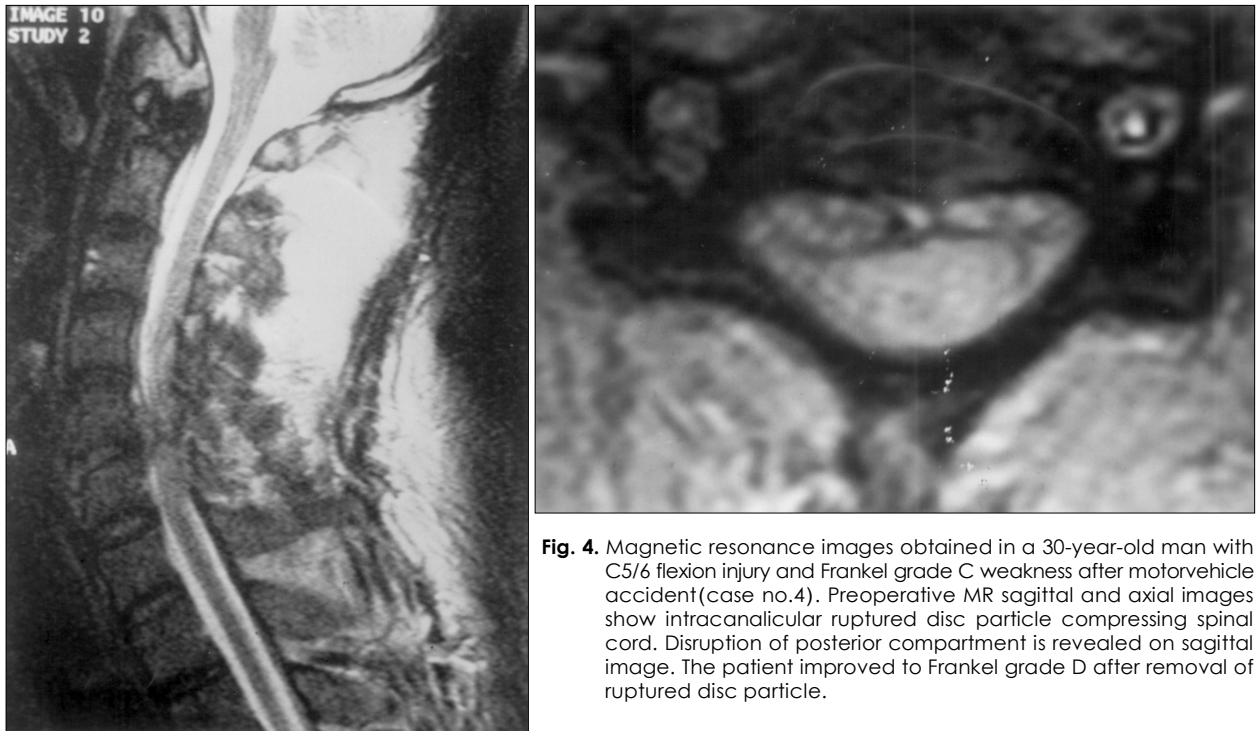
Magnetic resonance images obtained in a 30-year-old man with C5/6 flexion injury and Frankel grade C weakness after motorvehicle accident(case no.4). Preoperative MR sagittal and axial images show intracanalicular ruptured disc particle compressing spinal cord. Disruption of posterior compartment is revealed on sagittal image. The patient improved to Frankel grade D after removal of ruptured disc particle.
